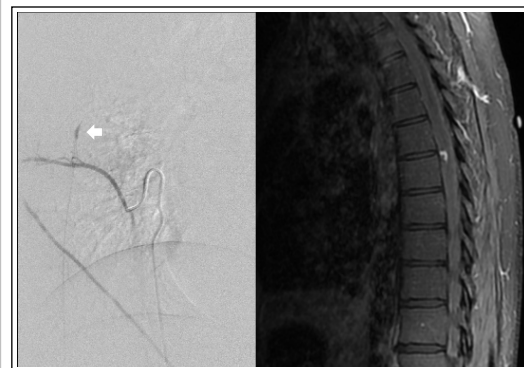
DSA with dissecting pseudoaneurysm of left T7 radiculomedullary artery. MRI sagittal T1 post-contrast with contrast-enhancing extramedullary, intradural nodule at T6-T7.
